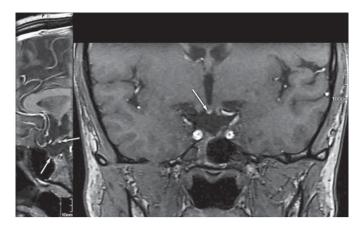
Pituitary morphology on MRI of a patient with MPHD of unexplained genetic cause: An ectopic posterior pituitary gland (bright spot), a hypoplastic anterior pituitary gland with only a rim of pituitary tissue and an invisible pituitary stalk are seen.
